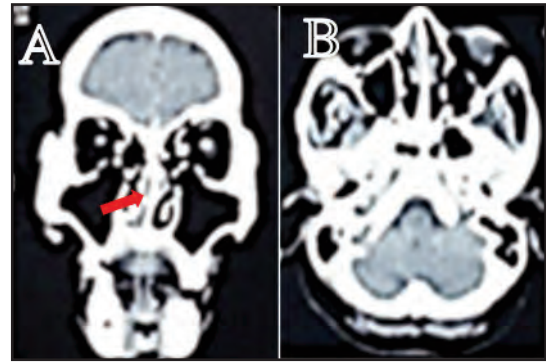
A head CT-scan results, presenting a coronal(A)-axial(B) section, the red arrows highlight the rupture in the nasal septum
